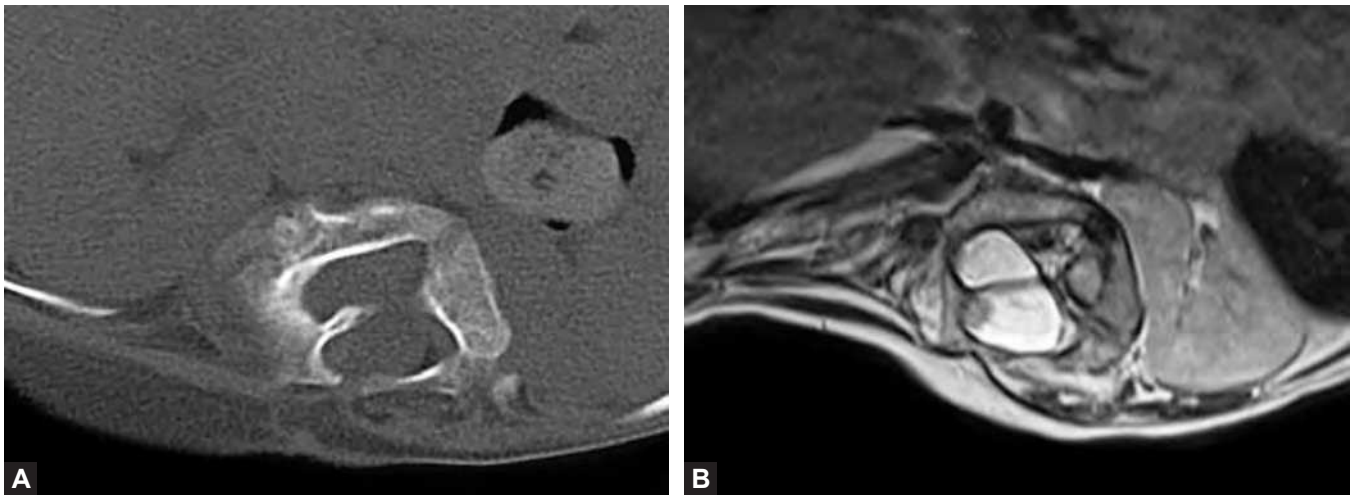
Axial T2 magnetic resonance imaging demonstrating type II split cord malformation with two hemicords in one dural sleeve.
